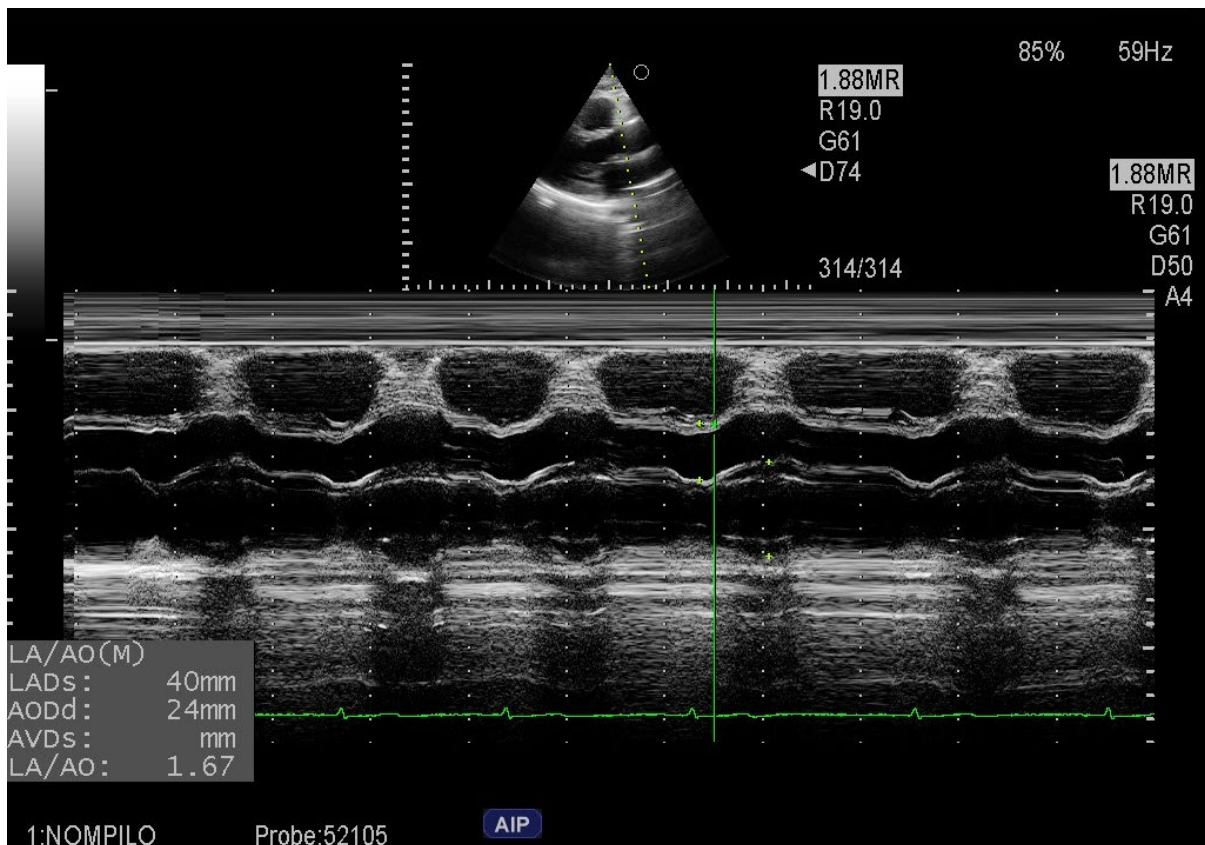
Parasternal long-axis view of LA/AO diameter using M-mode echocardiography.
